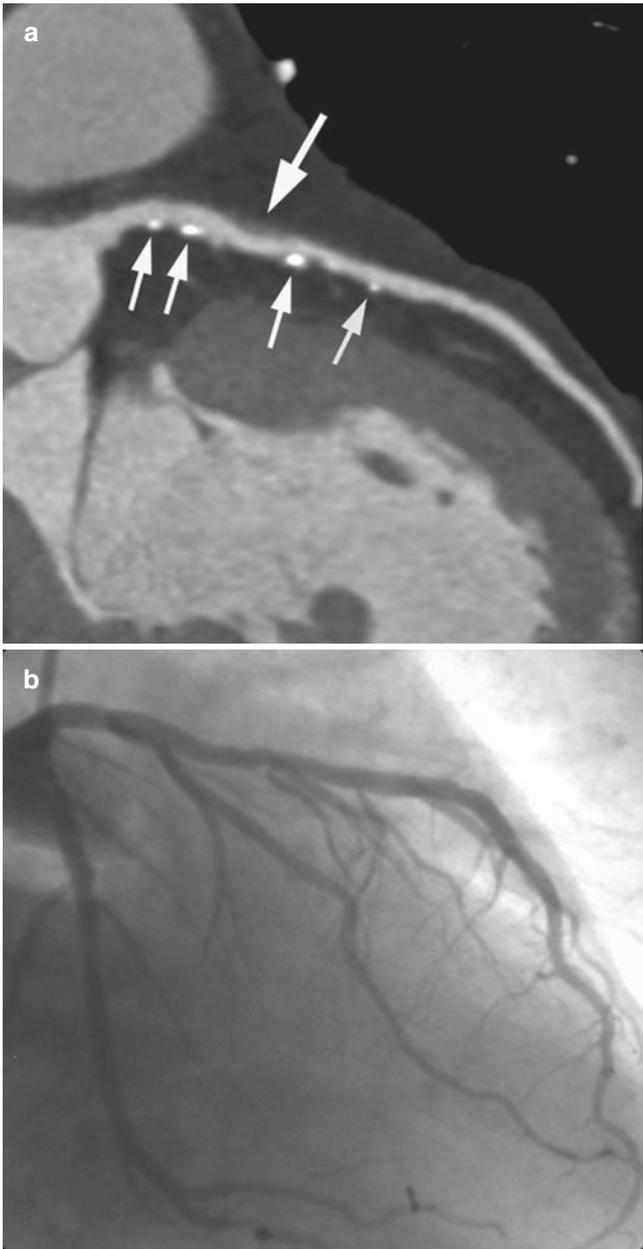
Detection of non-calcified plaque by contrast-enhanced CT angiography. (a) In this curved multi-planar reconstruction of the left main and left anterior descending coronary artery, several small coronary calcifications can be detected (*small arrows*) and, in addition, a larger non-calcified plaque is present. These atherosclerotic lesions do not cause a significant coronary artery stenosis. (b) Corresponding invasive coronary angiogram
